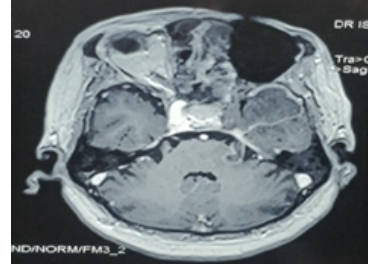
Axial cut MRI shows septic thrombosis of left cavernous sinus and involvement of left ICA.
